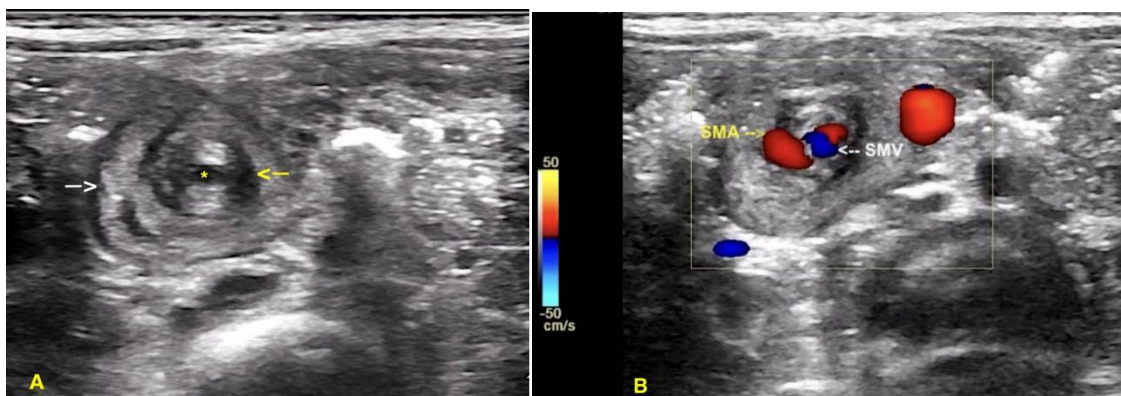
(A) Grey scale US shows clockwise swirling of SMV (yellow arrow) and small bowel (white arrow) around SMA (star*) in central abdomen. (B) Color Doppler image shows a (whirlpool sign) with inversion of the normal relationship between the SMV on the left and SMA on the right.
